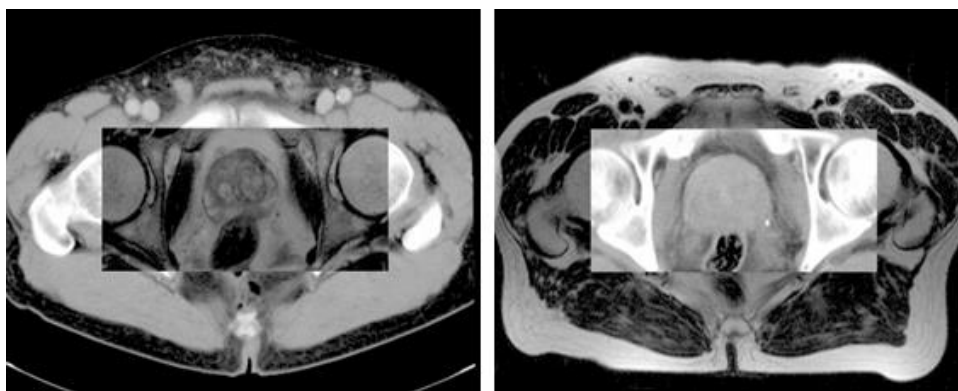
Example of fusion data from MR and CT by image registration. (left) MR overlaid on CT and (right) CT overlaid on MR [46].
